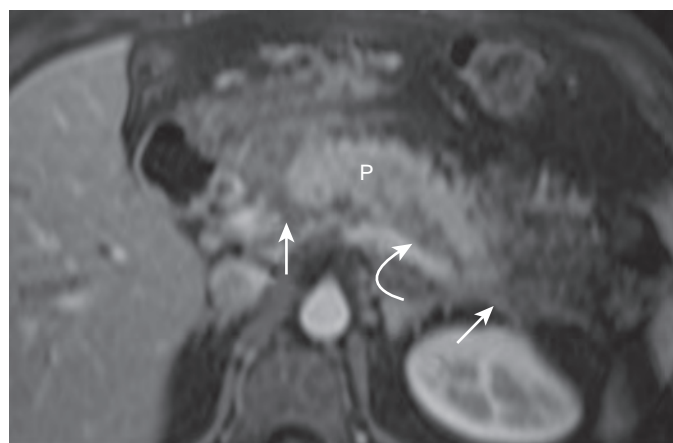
ERCP-induced pancreatitis with peripancreatic fluid collections. Axial enhanced T1-weighted fat-suppressed spoiled gradient-echo MR image shows heterogeneous pancreatic enhancement and peripancreatic fluid and inflammation (straight arrows). Fluid (curved arrow) is seen between the pancreas and the splenic vein. P, Pancreas. (From Miller FH, Keppke AL, Dalal K, et al: *MRI of pancreatitis and its complications: Part 1, acute pancreatitis*. AJR Am J Roentgenol 183:1637–1644, 2004. Reprinted with permission from the American Journal of Roentgenology.)
